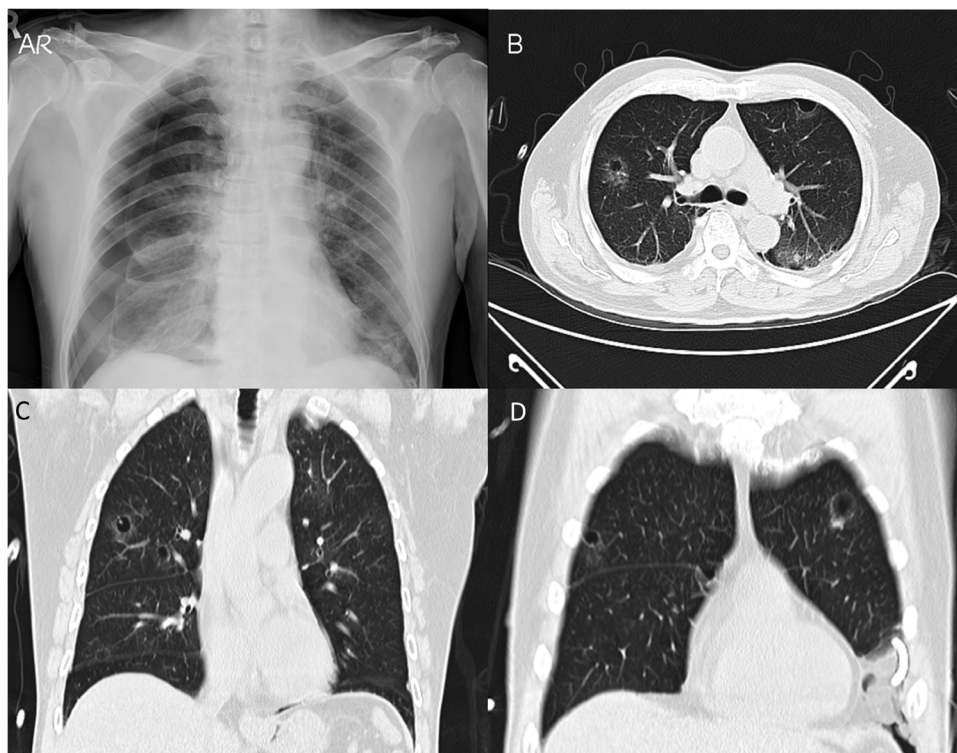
(A) Chest X-ray showing right side spontaneous pneumothorax. (B) Axial view of high-resolution computed tomography of the thorax demonstrating multiple cystic lesions with mild surrounding ground-glass opacities in both lungs.
